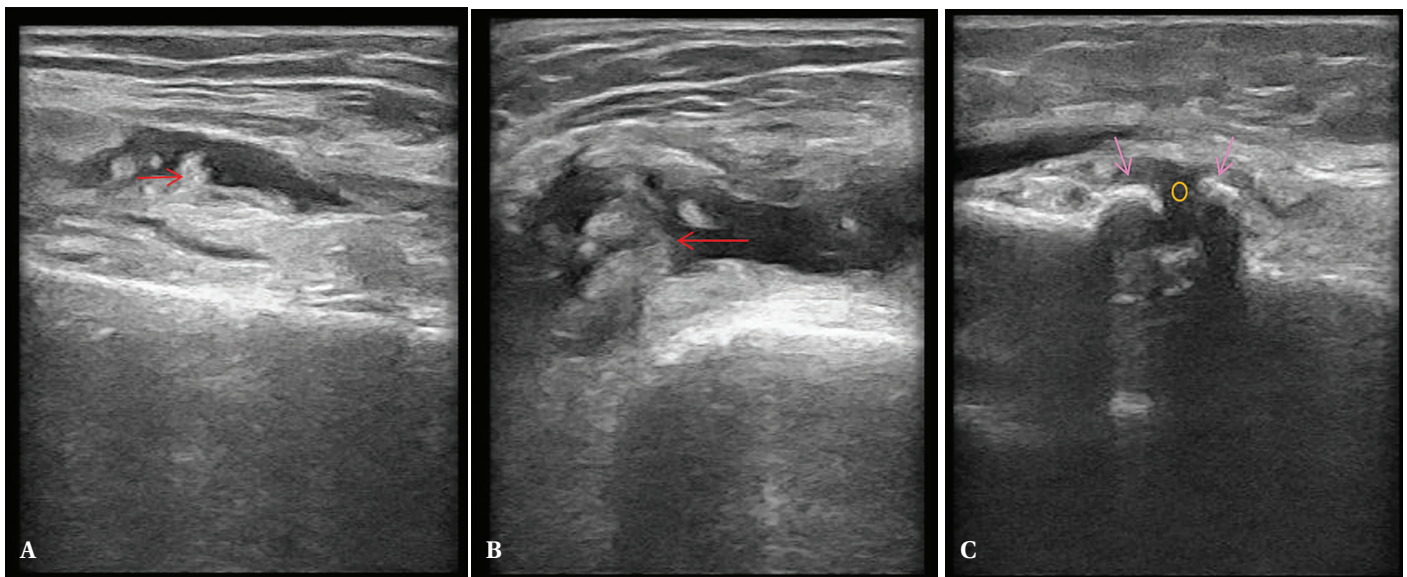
Knee ultrasonography. A, B) Effusion of knee and mass tissue (red arrow), C) Joint space (yellow circle) and osteophytes (purple arrow)
